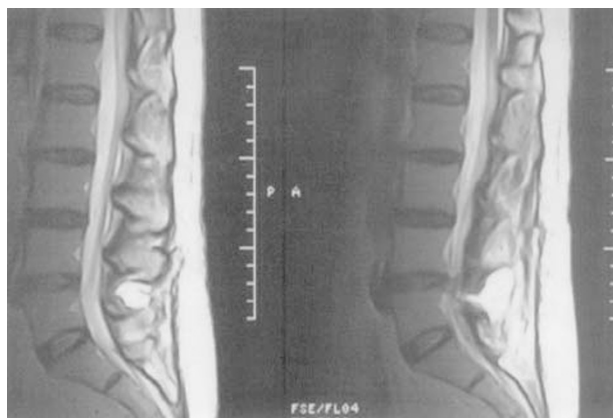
MRI (T2-weighted image) of the lumbar spine showing pseudomeningocele communicating with the subarachnoid space
